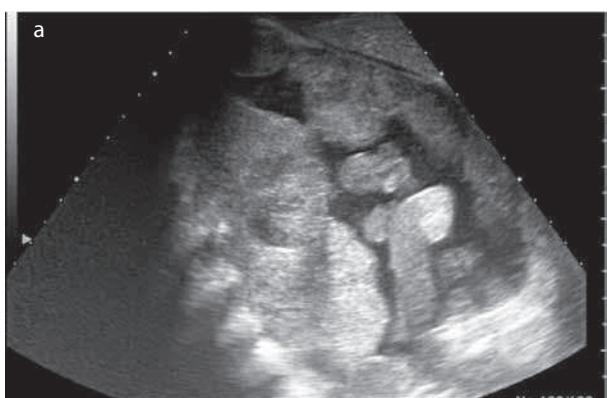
(a) Gray scale ultrasound (US) of right lung base with curved transducer: A solid mass with internal cystic and hemorrhagic areas; (b) Color Doppler US with linear transducer reveals internal vascularity of the right lung mass.
